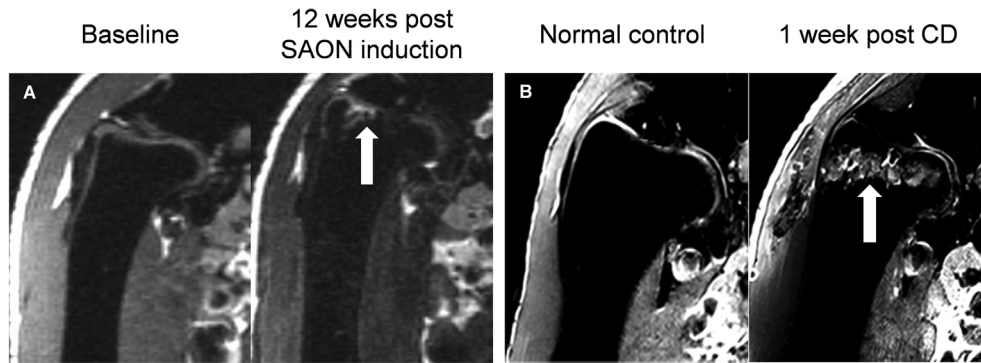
T2 weighed MRI showing SAON development and scaffold implantation. (A) Subchondral abnormal high signal (white arrow) in the right proximal femur was found 12 weeks after SAON induction. (B) MRI images of (left) normal control with intact hip and (right) a bone tunnel (white arrow) beginning from the lateral femoral cortex to the subchondral bone created by CD with scaffold implantation.
